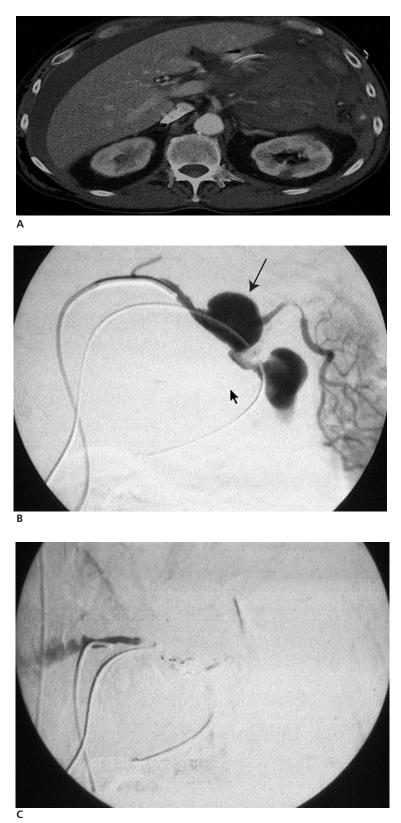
Pseudocyst hemorrhage can be treated with angiography. (A) The CT scan shows a large area of hemorrhage (arrows) in the region of the lesser sac. With metal coils (Gianturco), the bleeding pseudoaneurysm of the splenic artery (B, arrow) was embolized to control bleeding (C). (Courtesy of Henry I. Goldberg, MD.)
